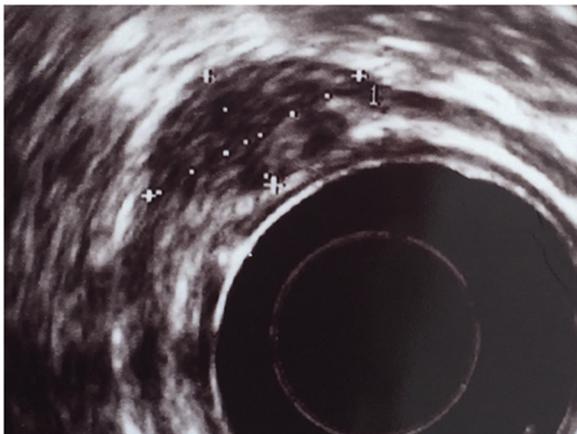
Endoscopic ultrasound shows a well-circumscribed 25 × 15 mm raised nodular hypoechoic lesion within the submucosal plane, positioned along the greater curve of the antrum.
